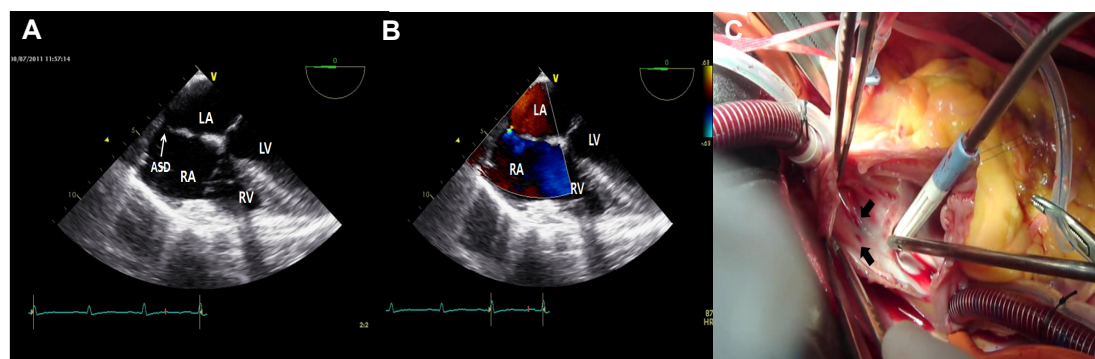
Two-dimensional (A) and color Doppler (B) echocardiography showing a small sinus venosus type of atrial septal defect with left to right shunt. During the operation, an internal view of right atrium of heart (C) showing two small sinus venosus types of atrial septal defect (black arrows). ASD, Atrial septal defect; LV, left ventricle; LA, Left atrium; RV, right ventricle; RA, right atrium.
